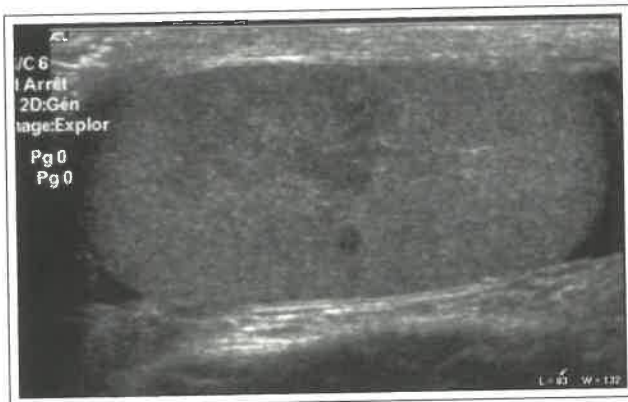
Sagittal view from scrotal sonogram shows a well demarcated lesion that is hypoechoic relative to adjacent normal testicle. This lesion has not mass.
